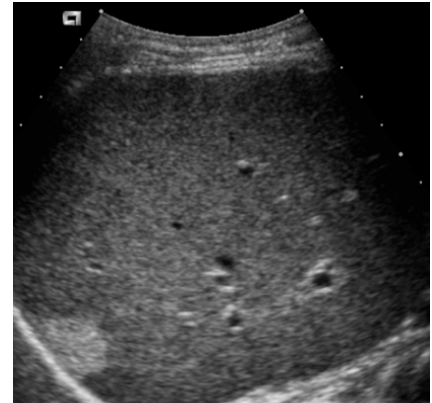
Ultrasound of liver showing a hyperechoic lesion typical of a haemangioma.
